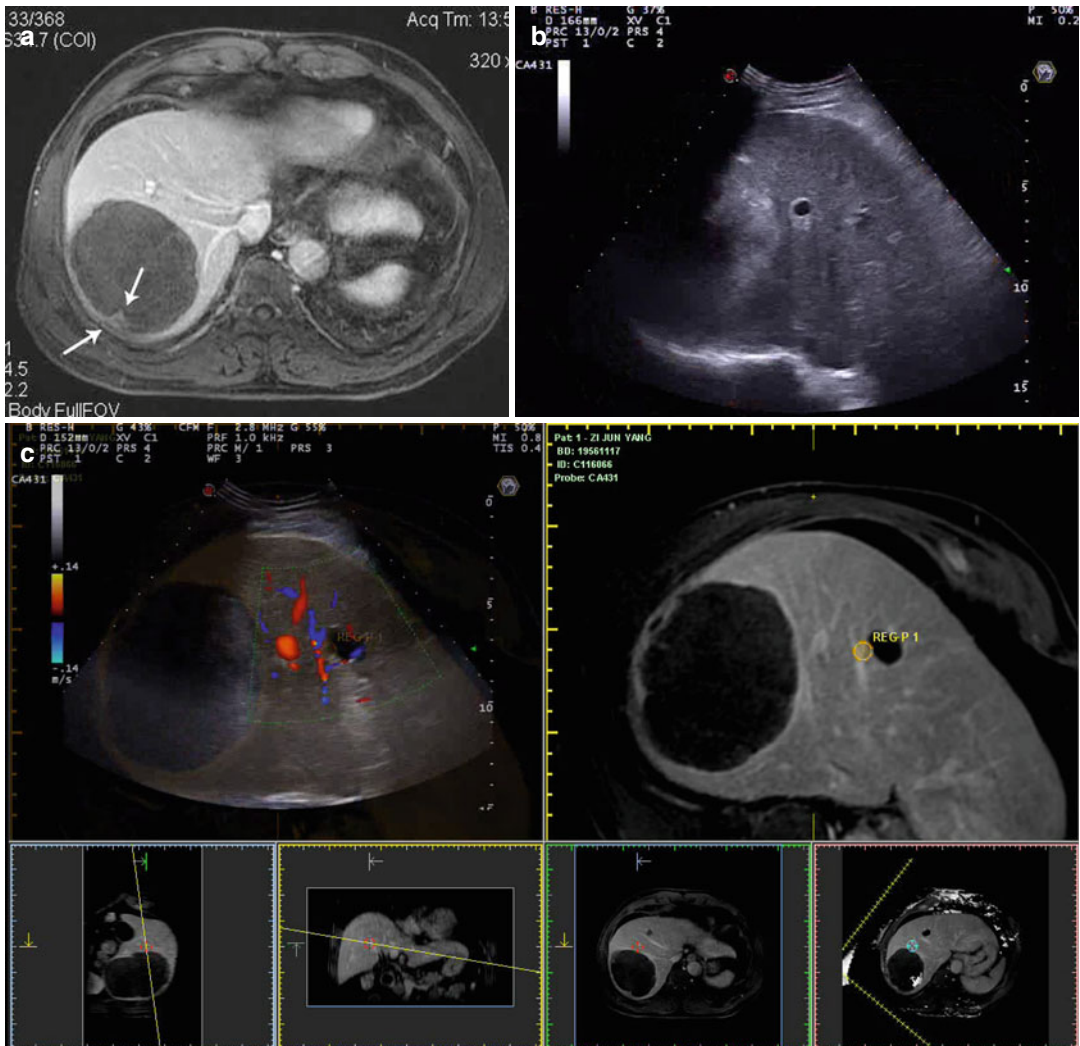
Images in a 54-year-old male with a 1.4×1.3 cm residual tumor of hepatocellular carcinoma (HCC) after transcatheter arterial chemoembolization in segment VII of the liver. (a) Contrast-enhanced magnetic resonance imaging (MRI) shows a residual tumor (arrows) adjacent to the diaphragm. (b) Conventional US could not detect the lesion. (c) Ultrasound (US) images and MR
